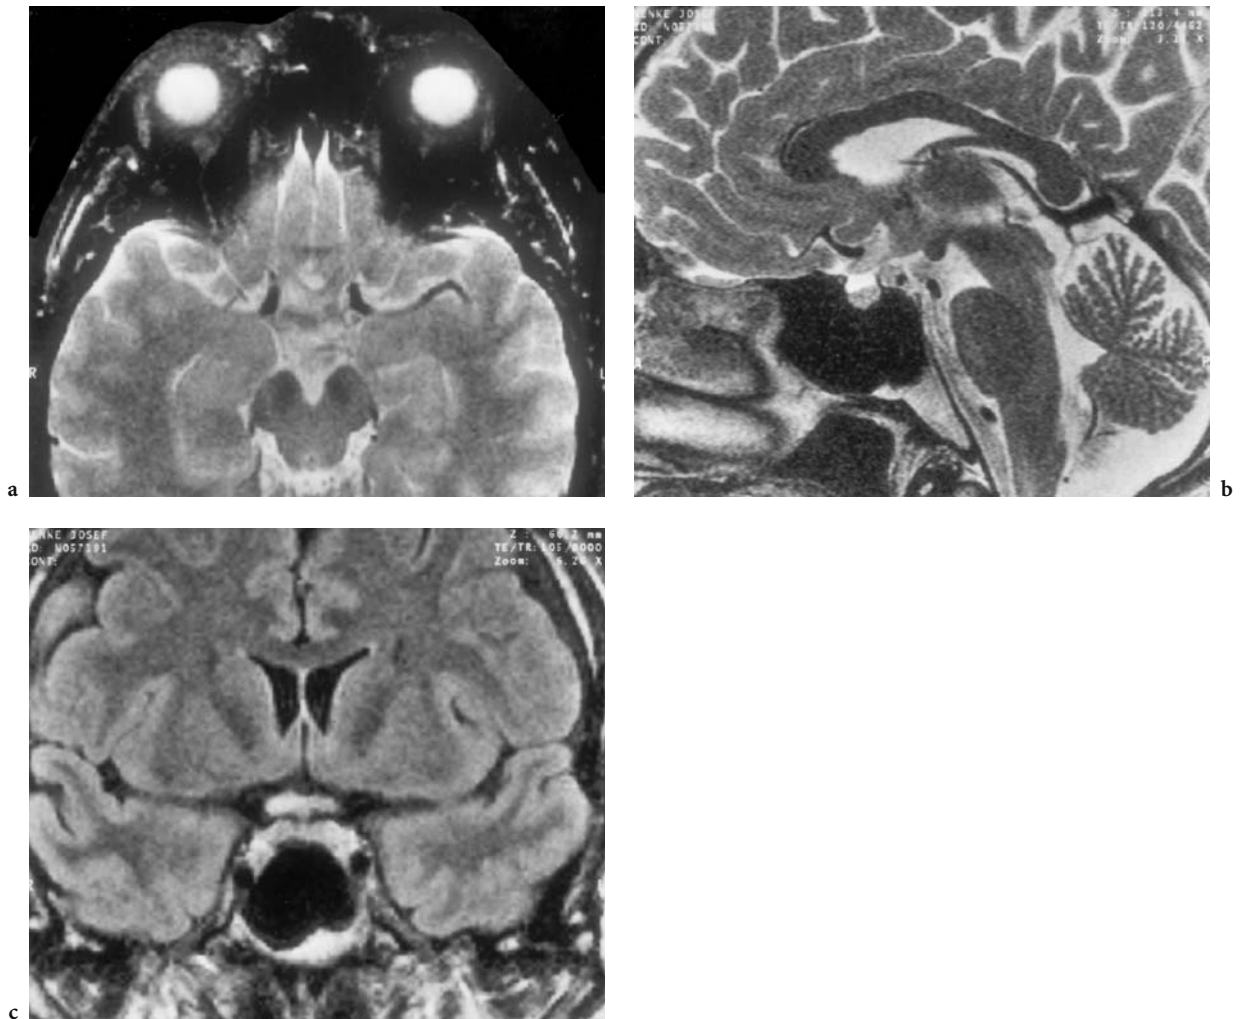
A 44-year-old man presenting with recurrent, alternating signs of bilateral retro-bulbar neuritis (RBN) with visual field defects and retardation on VEP without an afference defect; no pathologic findings on CSF and humoral immunology. Diagnosis: chiasmal edema of unknown origin. T2-weighted MRI: axial (a), sagittal (b), and coronal (c) (FLAIR) views demonstrating a thickening and high signal intensity of the entire chiasm with preference to the right. No systemic disorder could be found, but cortisone therapy diminished the subjective symptoms
